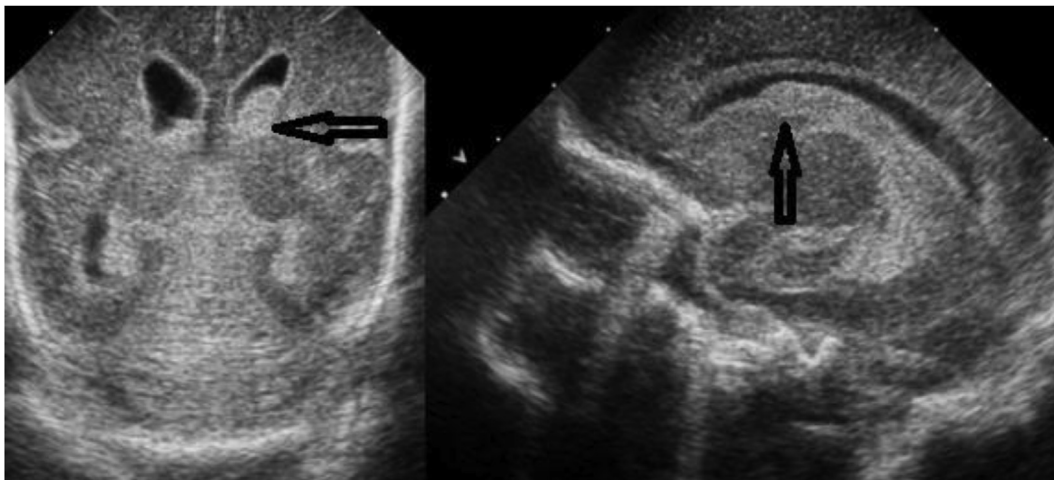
Coronal ultrasound scan of neonatal brain shows bilateral intra ventricular hyper echoic blood hemorrhagic changes (open black arrows) with moderate dilated both lateral ventricle prominent at the left side.
